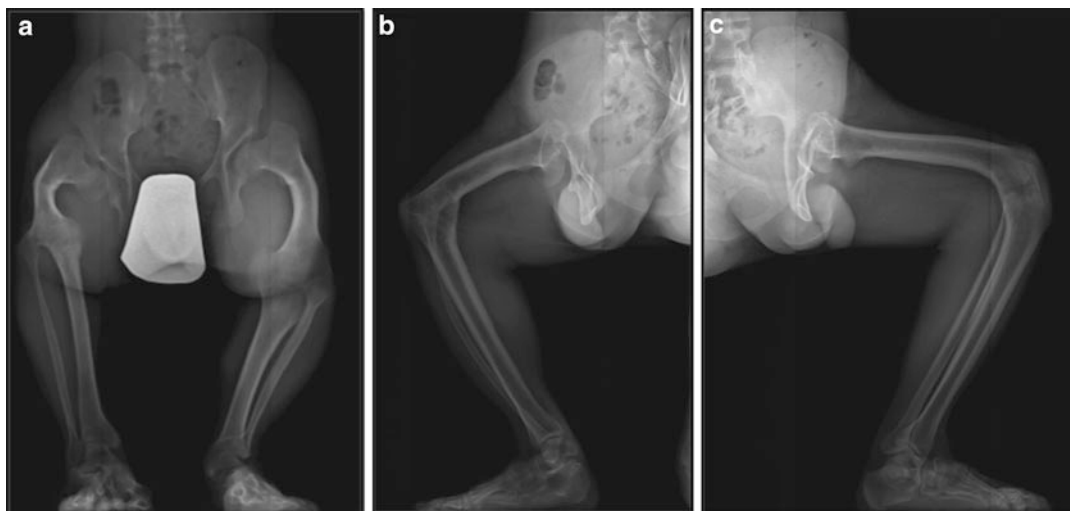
(a–c) AP and lateral full-length radiographs demonstrating bilateral coxa vara hip deformities and severe knee flexion deformities
